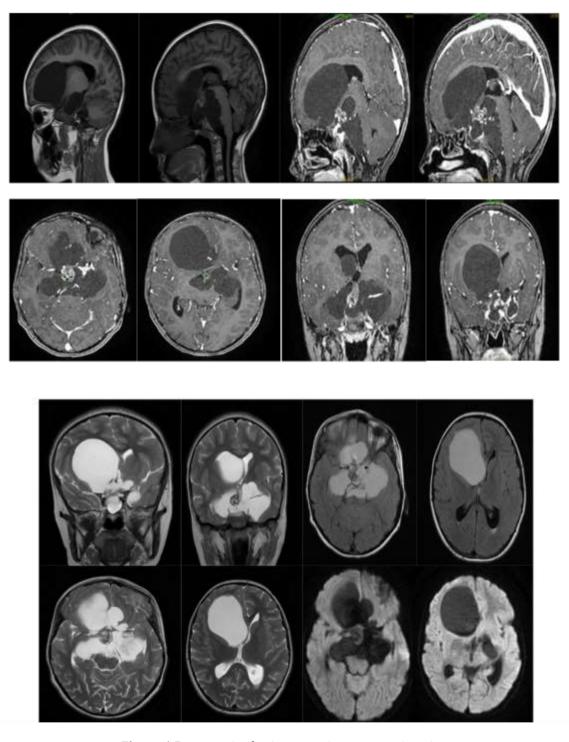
Preoperative brain magnetic resonance imaging.
